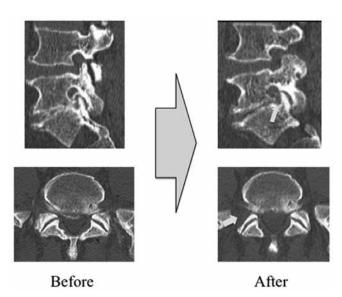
Computed tomography scans before and after the full-endoscopic lumbar foraminoplasty at the level of right L5-S. Arrows indicate the area of the foraminoplasty, indicating the foraminal widening, is clearly seen.
